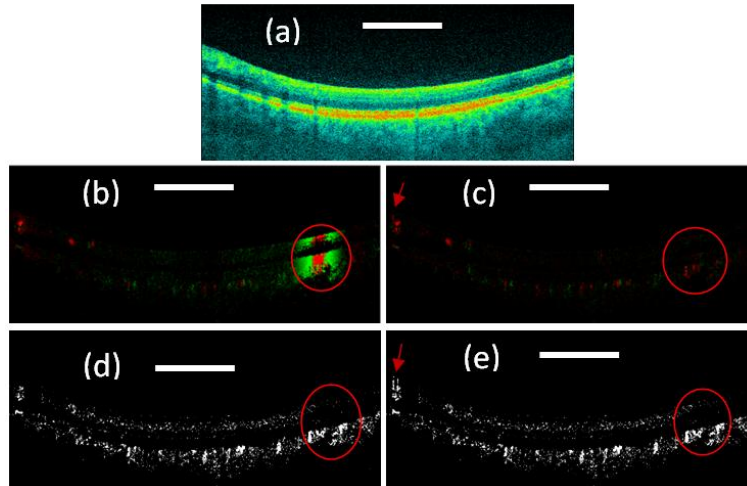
(a) OCT structure image; (b) Color Doppler OCT image without bulk motion correction; (c). Color Doppler OCT image with bulk motion correction; (e) Doppler variance OCT image without bulk motion correction; (f) Doppler variance OCT image with bulk motion correction. Scale bar: 1mm.
